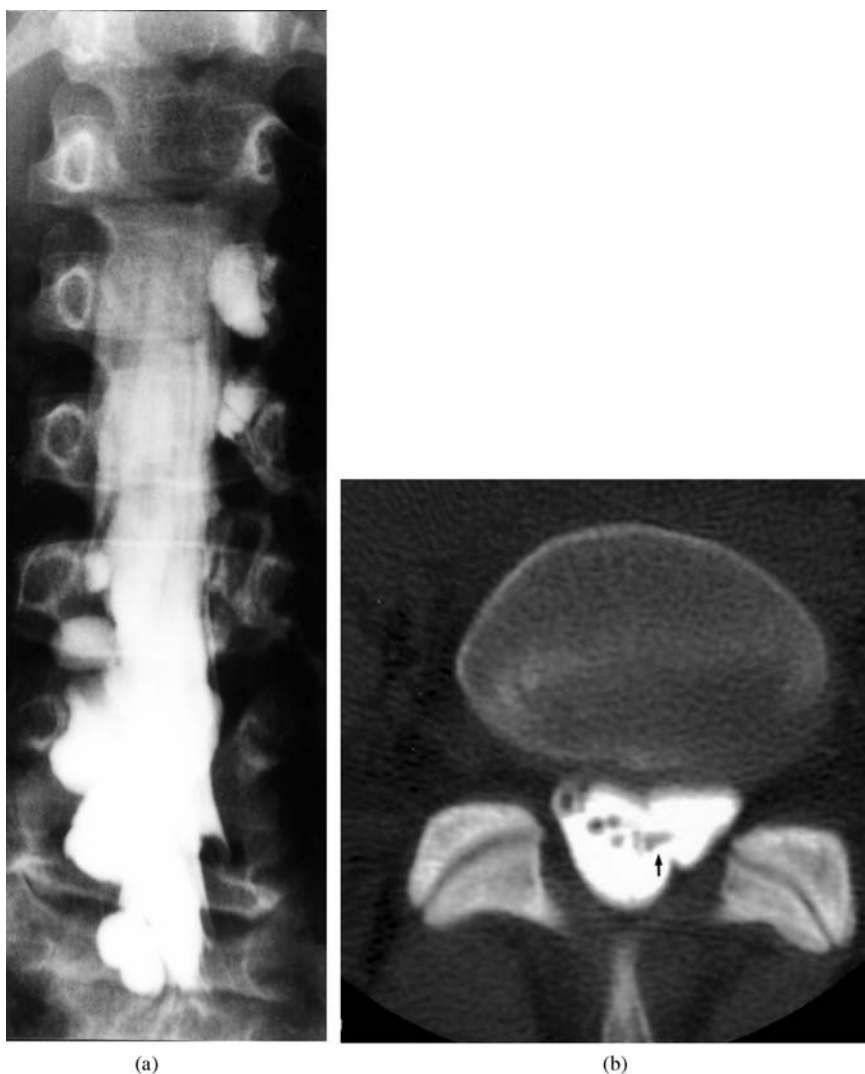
Myelogram and CT myelogram obtained of lumbosacral plexus lesions with meningoceles and ruptures of roots in the cauda equina. (a) Myelogram revealing numerous bilateral traumatic meningoceles with leakage of contrast material on the left from lumbar roots and on the right from L4 downward. (b) CT myelogram at the L5–S1 level revealing the few remaining roots and an anterior cyst in continuity with the subarachnoid space. Note the proximal root stump at the transition between the subarachnoid space and the cyst (arrow) available for reconstruction by means of nerve grafting (from Lang *et al.* 2004).
